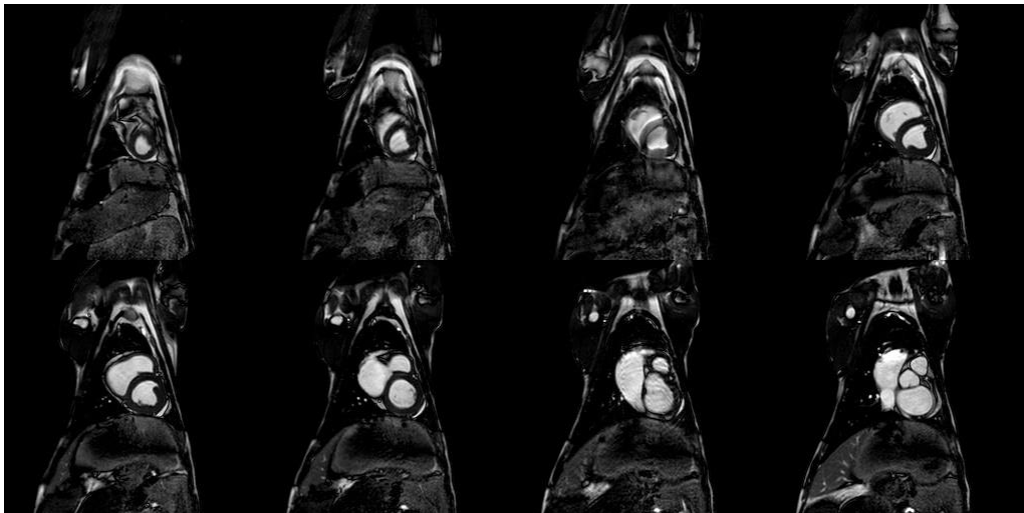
Left ventricle short axis slices acquired with MRI at end systole
